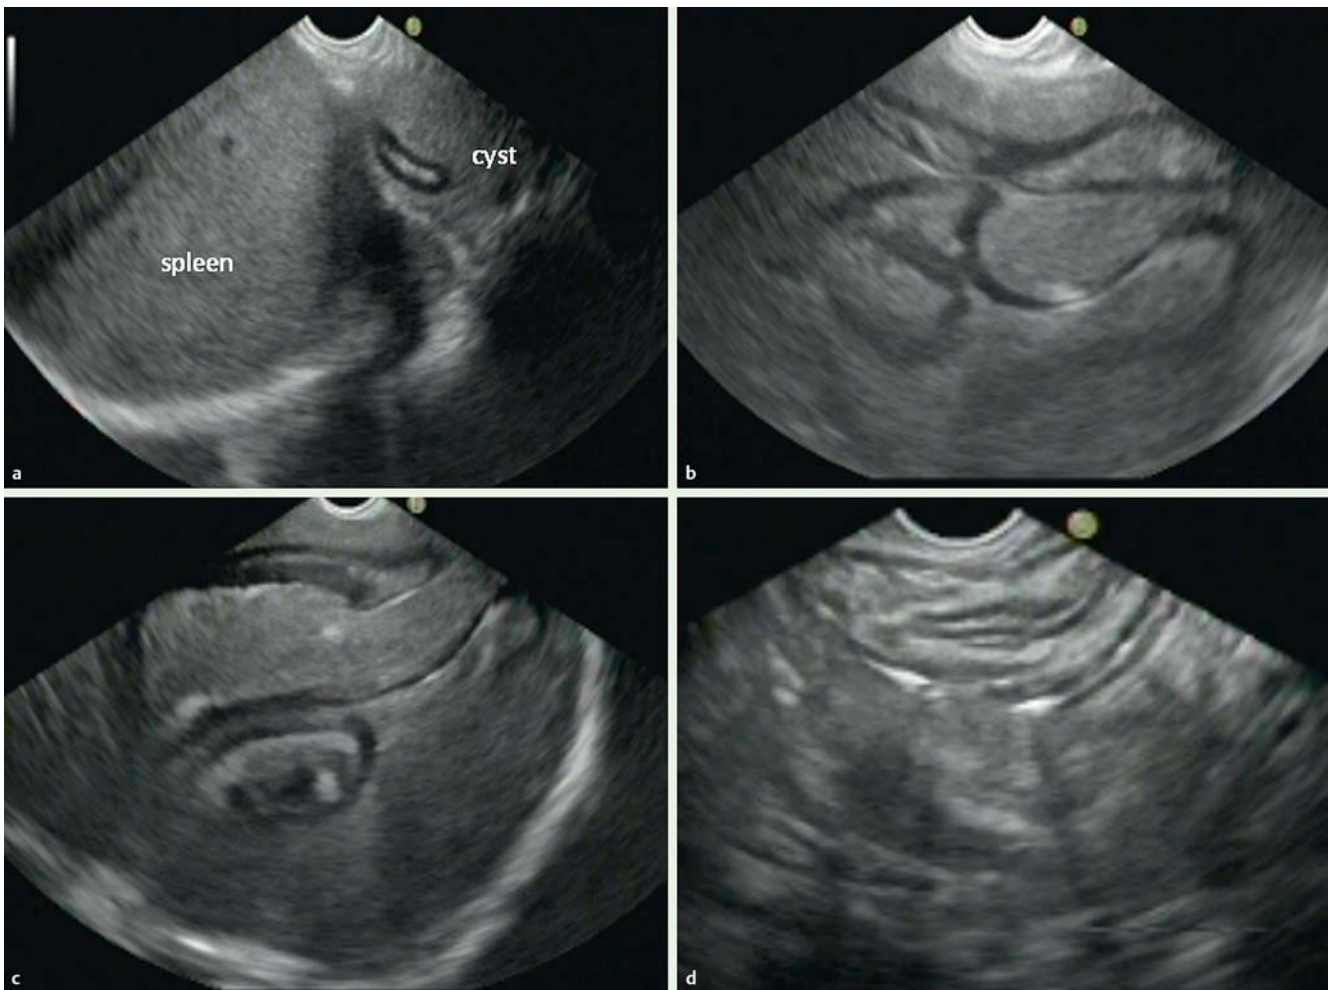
Endoscopic ultrasound (EUS) appearances of a hydatid cyst. a A large cyst continuous with the spleen. b Multiple serpentine structures representing collapsed membranes were seen within the cyst cavity. c A daughter cyst with echogenic material. d Calcifications were also noted within the cyst cavity and on the cyst wall.
